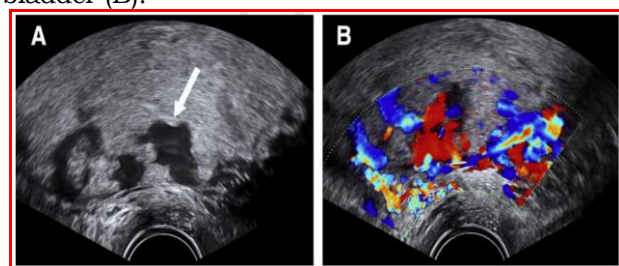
Transvaginal ultrasound views of placenta previa increta at 20 weeks. A, "Moth-eaten" appearance of placenta with numerous lacunae of different sizes and shapes secondary (arrow); and B, high-velocity, turbulent blood flow within lacunae on color Doppler imaging.
